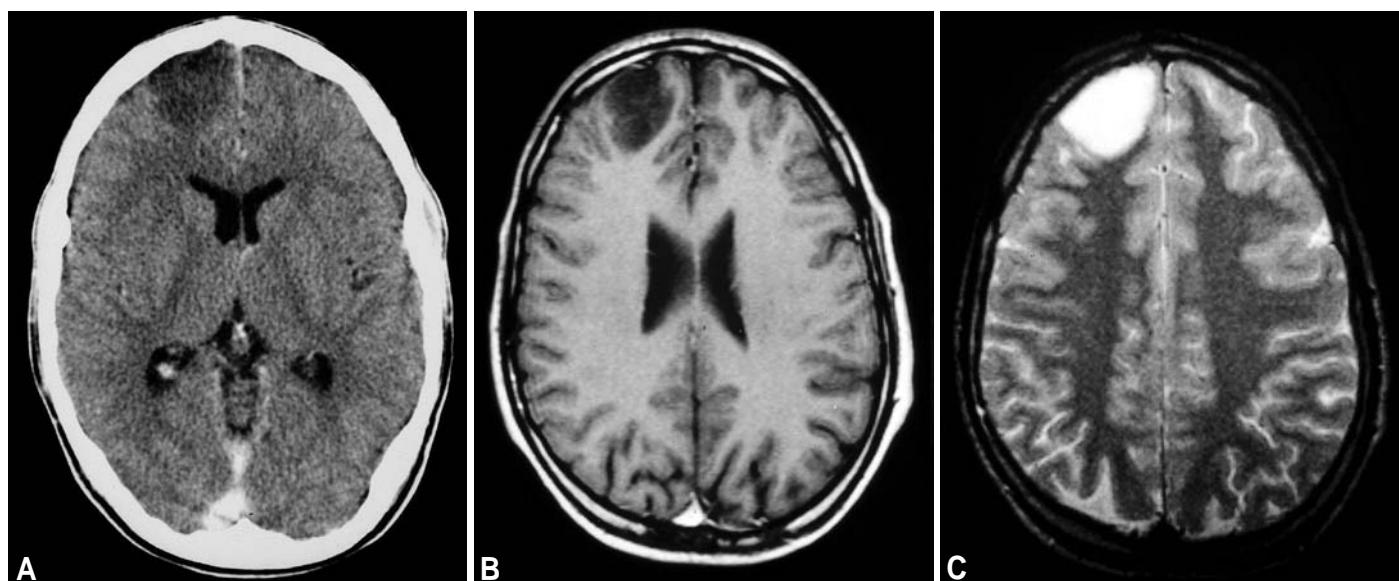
Diffuse astrocytoma WHO grade II, presenting as (A) hypodense frontal lesion on contrast-enhanced CT, as (B) hypointense focus on gadolinium-enhanced MRI and (C) as well-delineated hyperintense lesion on T2-weighted MRI.
